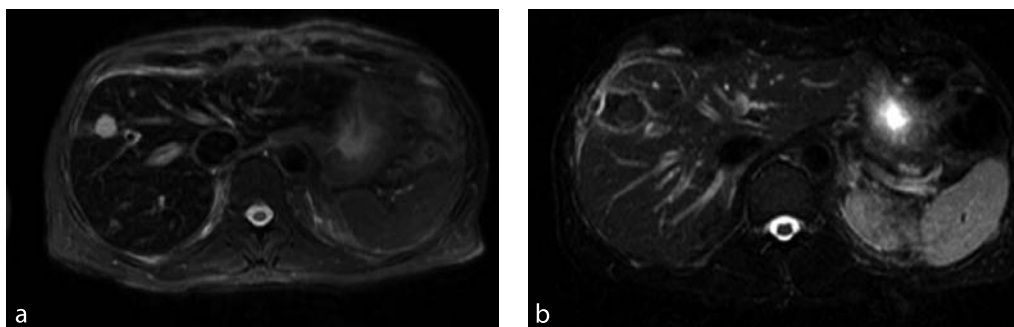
a MRI of a patient with solitary liver metastasis of an adenocarcinoma. T2-W images demonstrated a highly hyperintense tumor because of a high concentration of water-bounded protons in the tumor. b Five days after radiofrequency ablation, the signal intensity of the tumor and the surrounding tissue is reduced because of coagulation and complete necrosis of the treated area. A small hyperintense rim caused by inflammation around the necrotic area is visible
